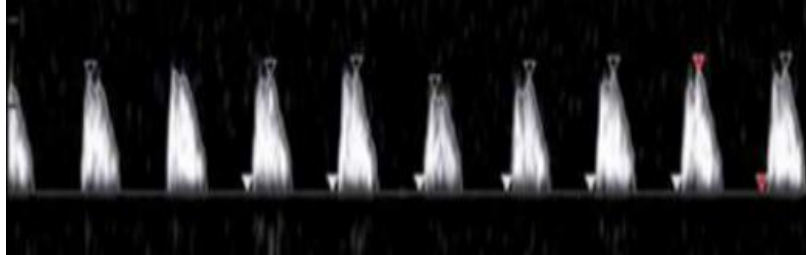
FIGURE IC: ABSENT DIASTOLIC FLOW IN MIDDLE CEREBRAL ARTERY DOPPLER
